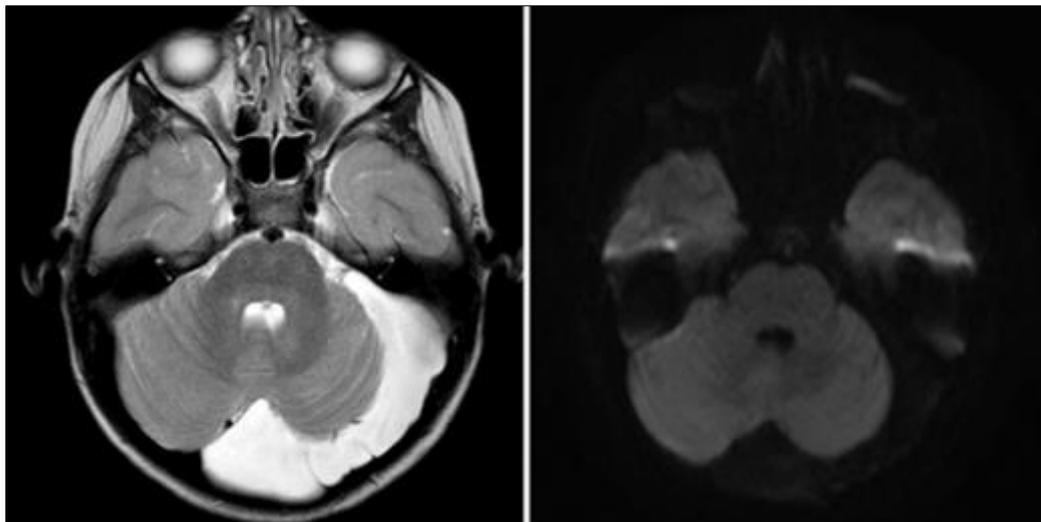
Axial T2W brain image and DWI image show prominent CSF space behind the left hemis cerebellum that contains few incomplete folds. Normal vermis, fourth ventricle and torcula. No restricted diffusion. Findings consistent with Mega cisterna magna
